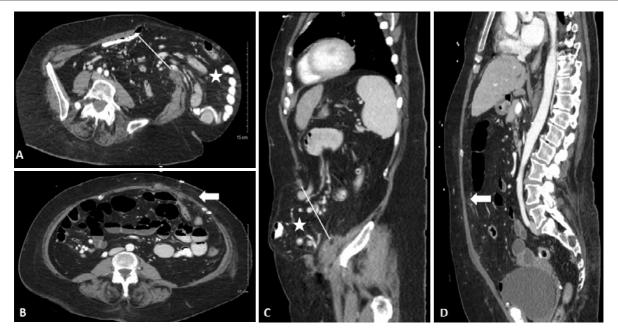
A. Preoperative axial view CT demonstrating transverse dimensions of hernia defect (white line) and hernia pouch (white star). B. Postoperative axial view CT showing complete resolution of hernia defect and reduction of hernia pouch contents into the peritoneal cavity (white arrow). C. Preoperative sagittal view CT demonstrating vertical dimensions of hernia defect (white line) and hernia pouch (white star). D. Postoperative sagittal view CT showing complete resolution of hernia defect and reduction of hernia pouch contents into the peritoneal cavity (white arrow).
